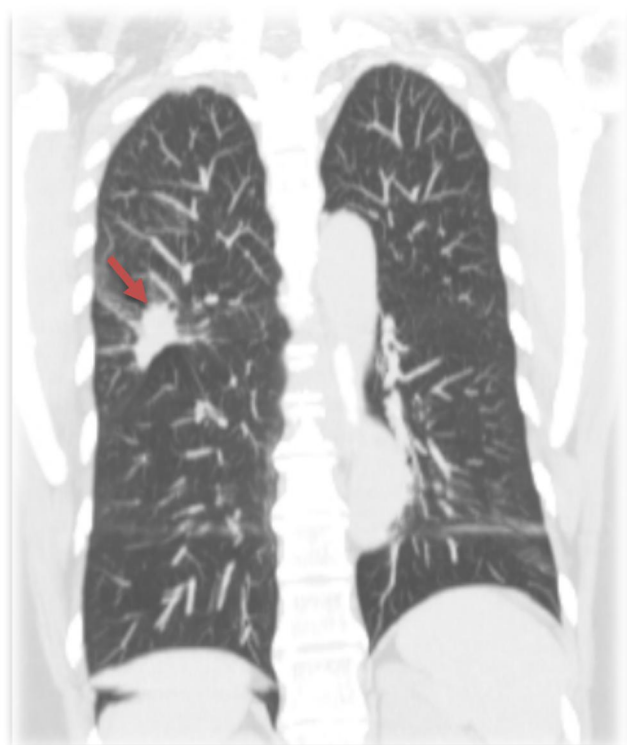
A coronal CT scan in 2007, revealed right upper lobe lung mass (arrow).
